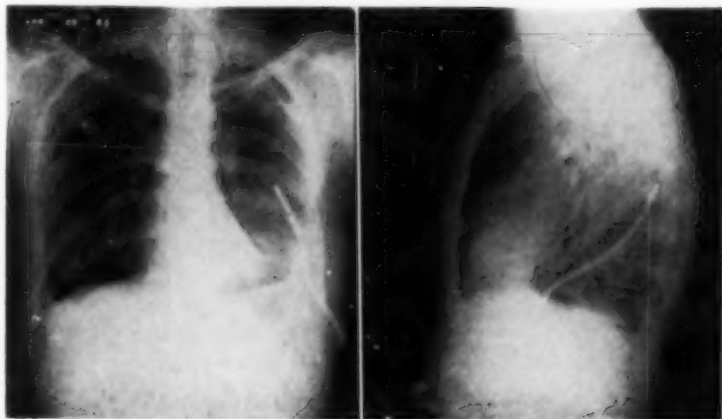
Case 2: Tuberculous empyema, left. Roentgenogram following fourth instillation of tryptar. Intercostal tube in place.
